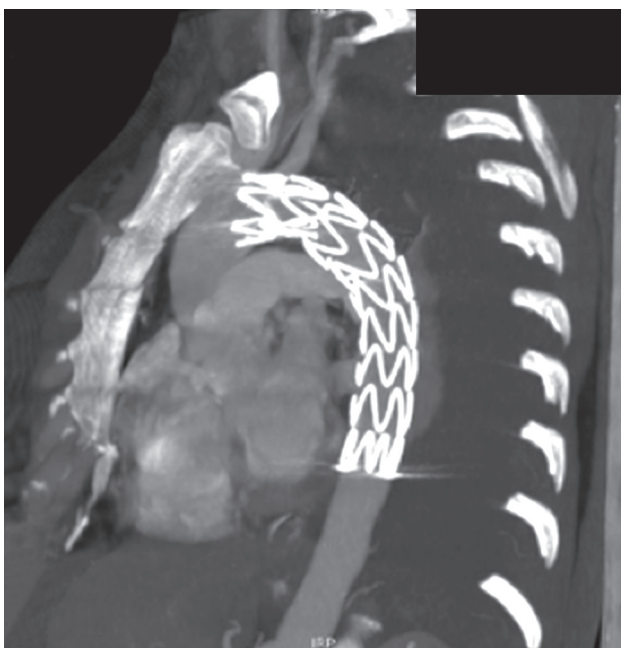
Postoperative computed tomography (sagittal plane).
